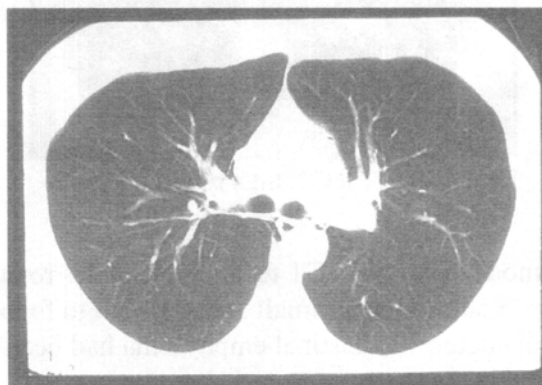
Chest CT of a 27 year old military diver (Case 5).
